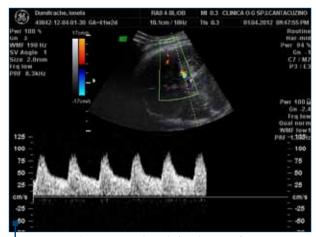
Doppler spectrum 36 hours before the onset of spontaneous labor
